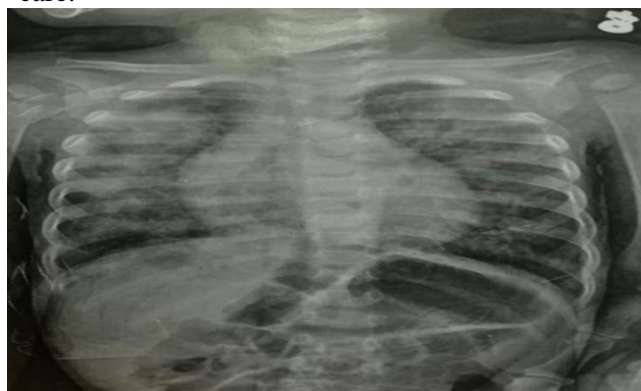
Chest X-ray (anteroposterior view) showing bilateral pulmonary hemorrhage.
